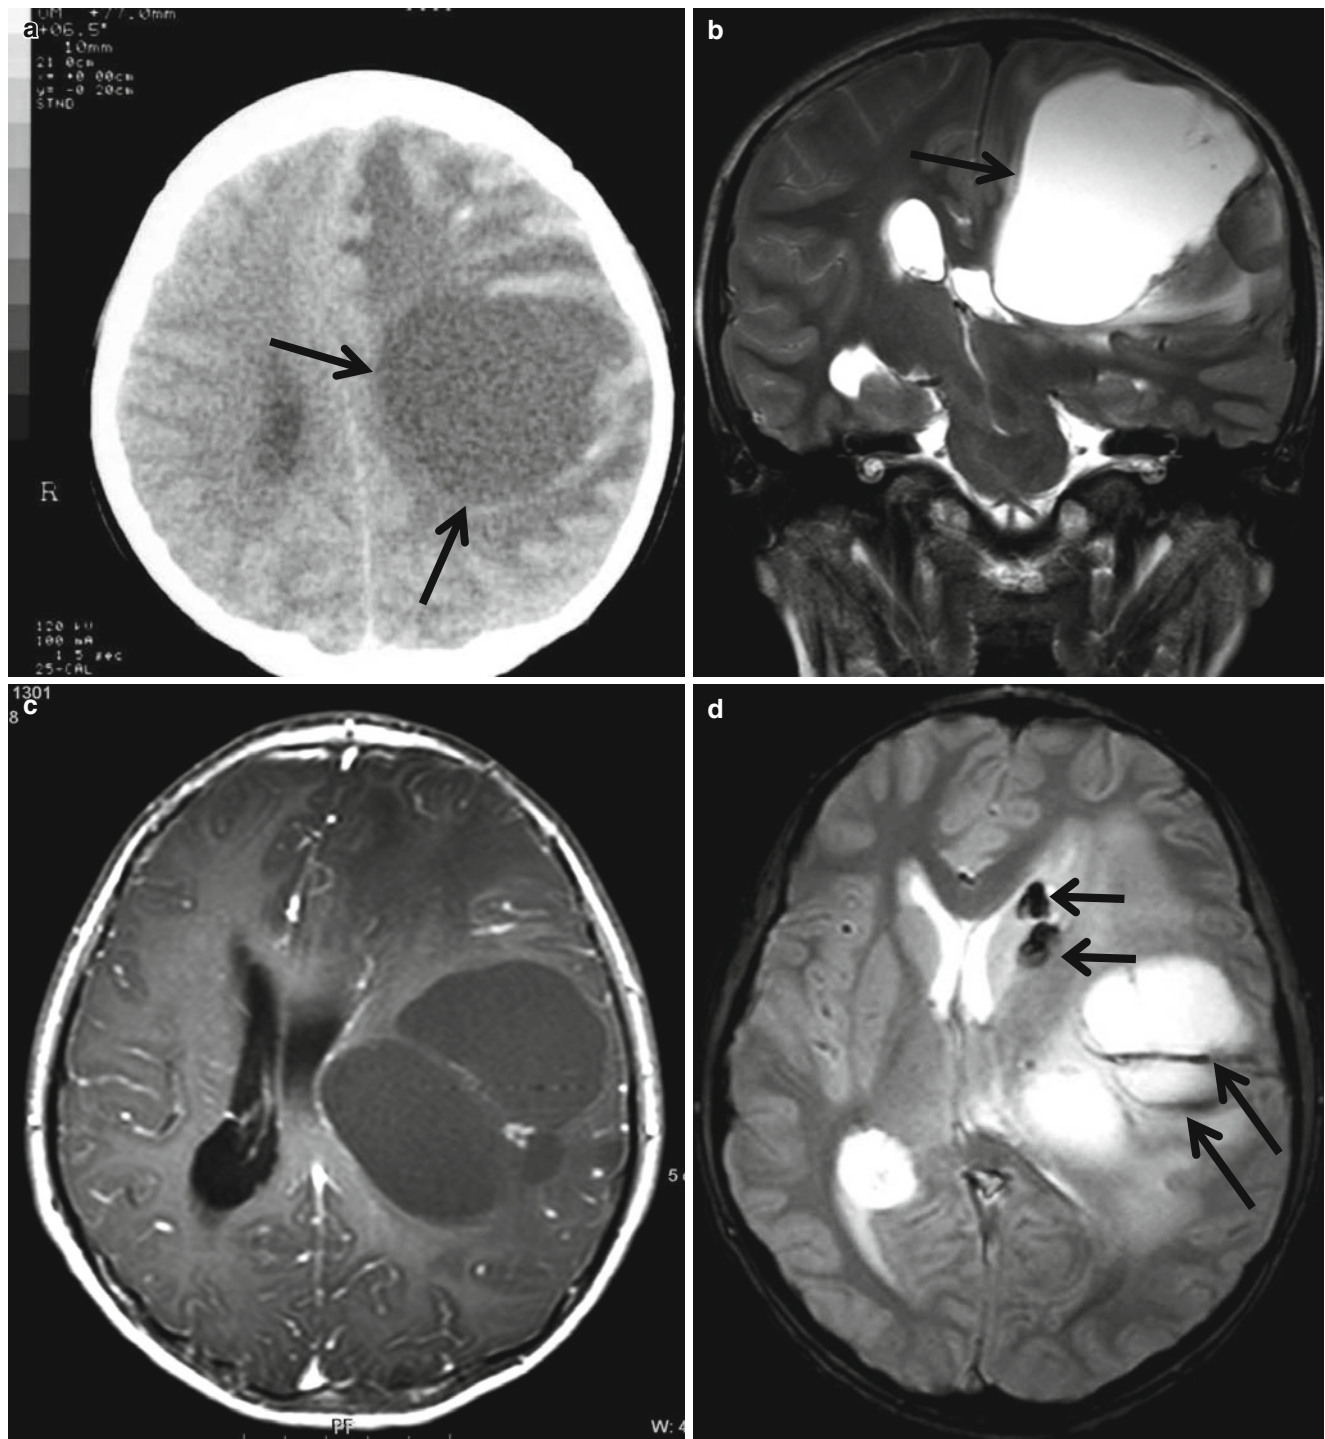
Giant cavernous malformation mimicking brain tumor. (a) Precontrast CT scan shows large cystic mass with massive surrounding edema. (b) T2-weighted coronal image shows large cystic mass (arrow) with edema and mass effect. (c) The mass is not well enhanced on a
